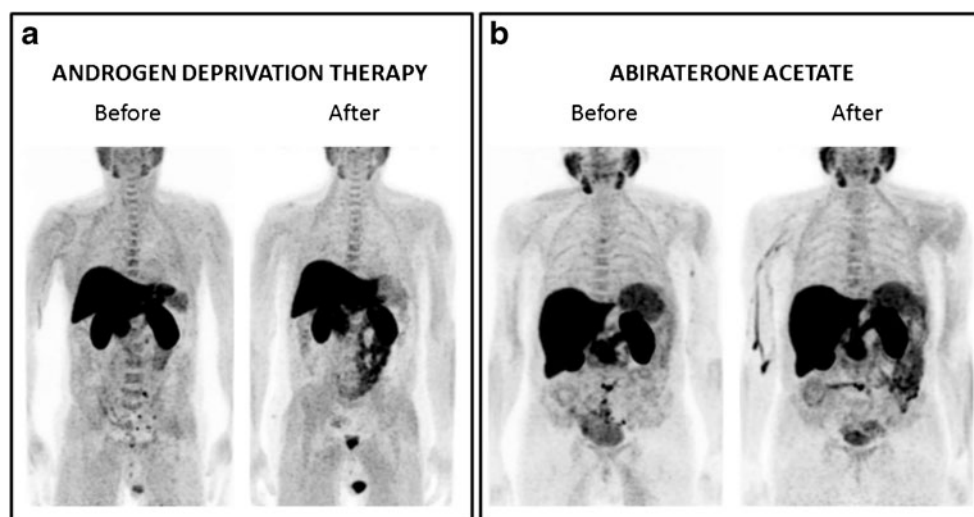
a A 67-year-old man with PCa treated by radical prostatectomy and lymph node dissection (pT3bN1; GS: 9; positive margins). Serial monthly PSA (0.56 ng/mL- > 2.37 ng/mL- > 3.03 ng/mL) demonstrated biochemical failure, with significant uptake of ^{18}F -fluoroethylcholine in the abdominal-pelvic lymph node on PET/CT images (*left*), and thus treatment with LH-RH agonists was started. Six months after the start
